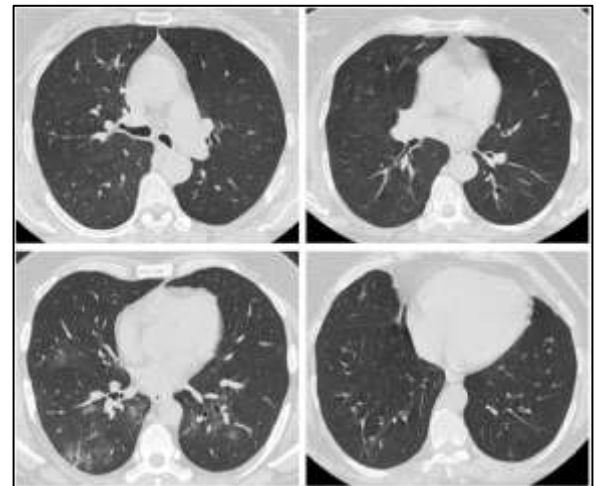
Axial CT images in lung window in a 70-year-old female. Few patches of GGO were noted in the central and peripheral distribution in the bilateral lower lobes and right middle lobe. Ct severity score 5/25. This patient had normal TLC, SGOT, SGPT, CRP, D-dimer, IL-6, S. Ferritin, LDH however had a low percentage of lymphocytes in DLC.
